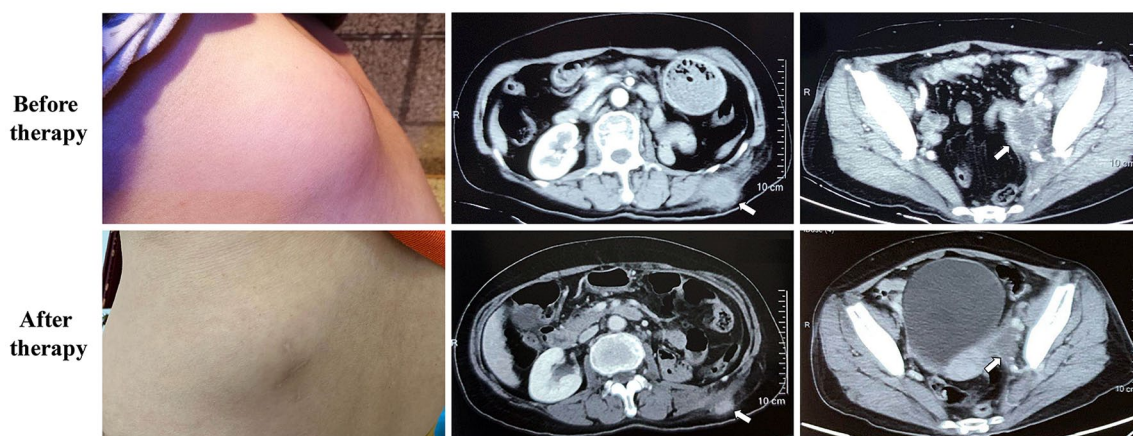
Images of the lesion changes reflected the therapeutic response following Olaparib therapy. The waist lesion can be observed from the body surface and reduced after therapy (left column). CT images show that the waist lesion reduced following Olaparib therapy (middle column, arrows indicate the lesion). CT images show that the pelvic lesion reduced following Olaparib therapy (right column, arrows indicate the lesion). CT, computed tomography.
